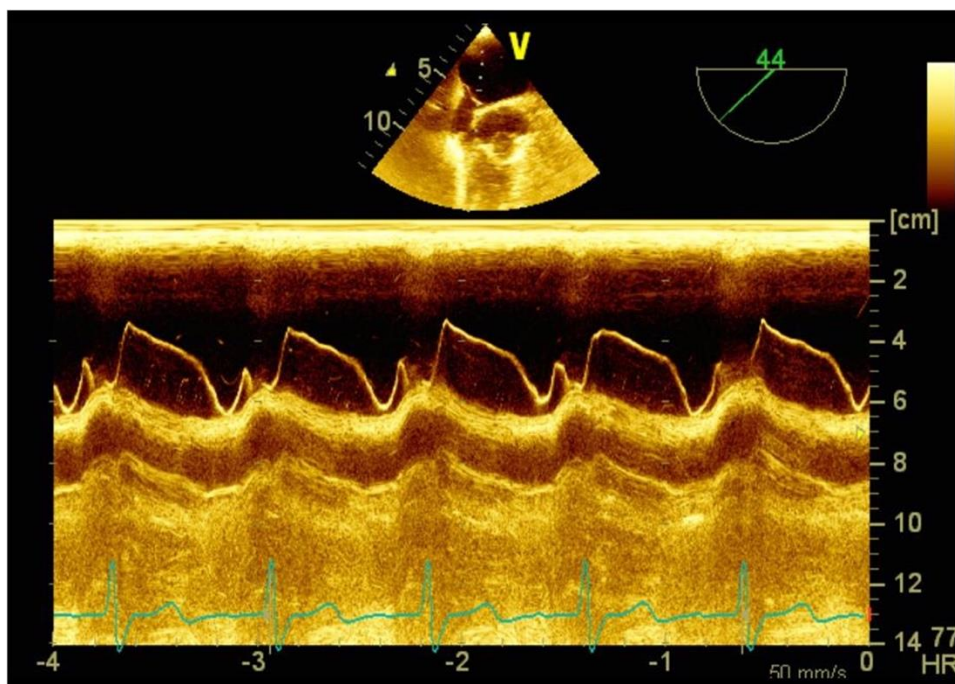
Transesophageal echocardiography: excursion of the interatrial septum in M mode
